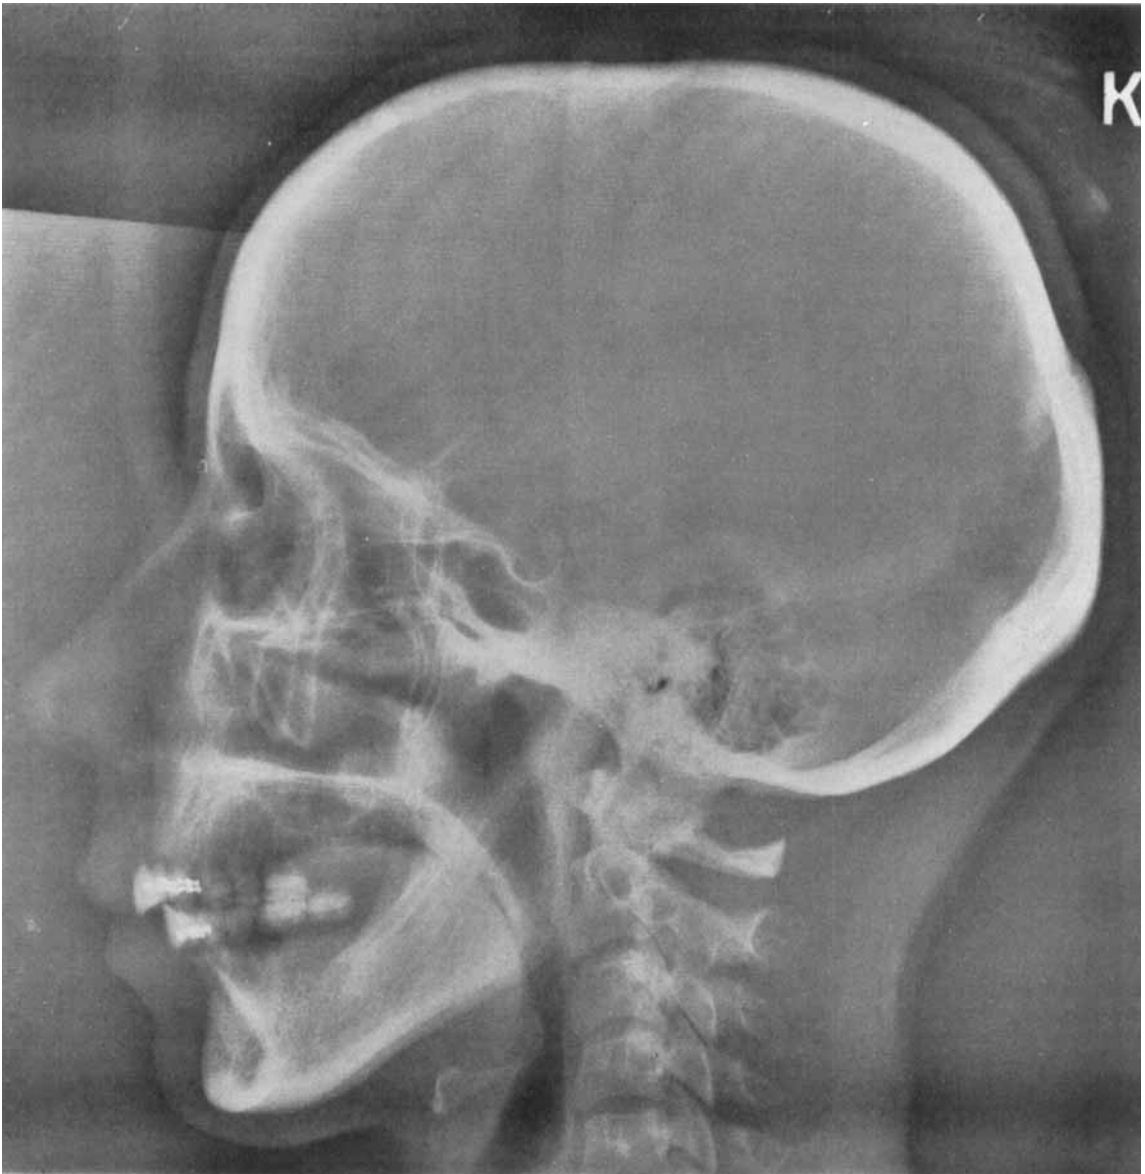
a. Profile radiograph in occlusal position upon insertion of complete dentures 3 months after extraction of the teeth.
